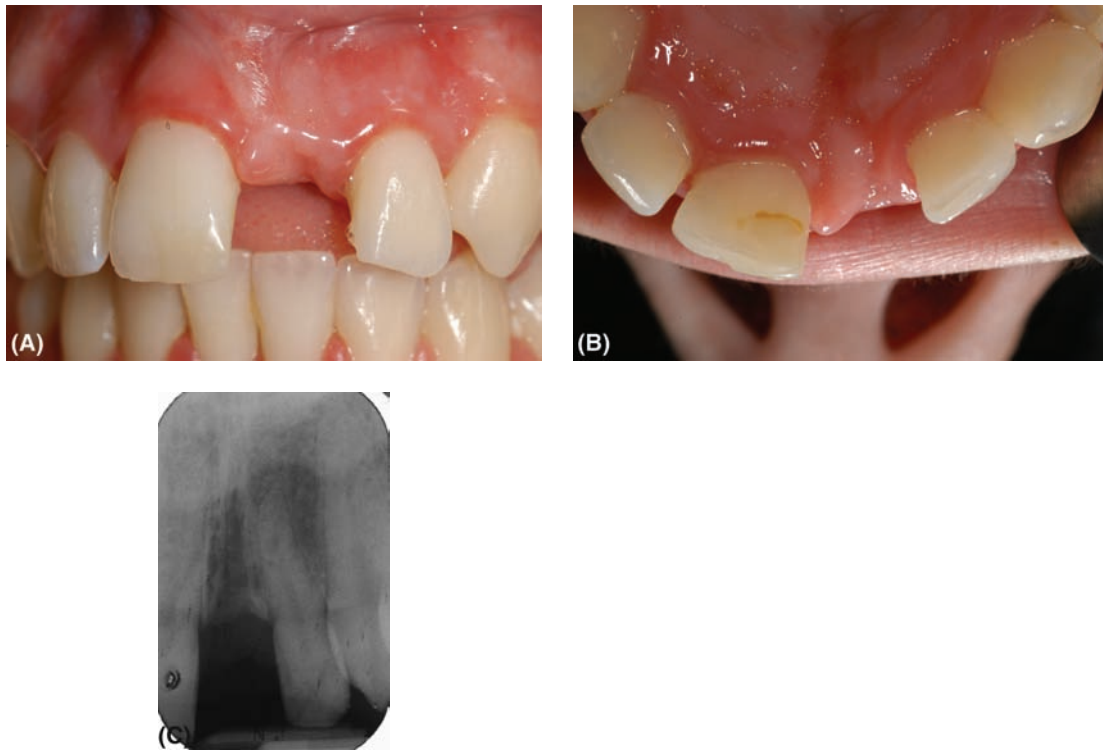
(A) The labial view of the missing maxillary central incisor suggests good ridge height and morphology. (B) The occlusal view of the same case shows a prominent incisive papilla and relatively narrow space. (C) A radiograph of the case shows that the incisive canal occupies most of the edentulous space and there is slight convergence of the adjacent tooth roots. If an implant were planned, this may require both orthodontic tooth movement and bone grafting of the incisive canal.
